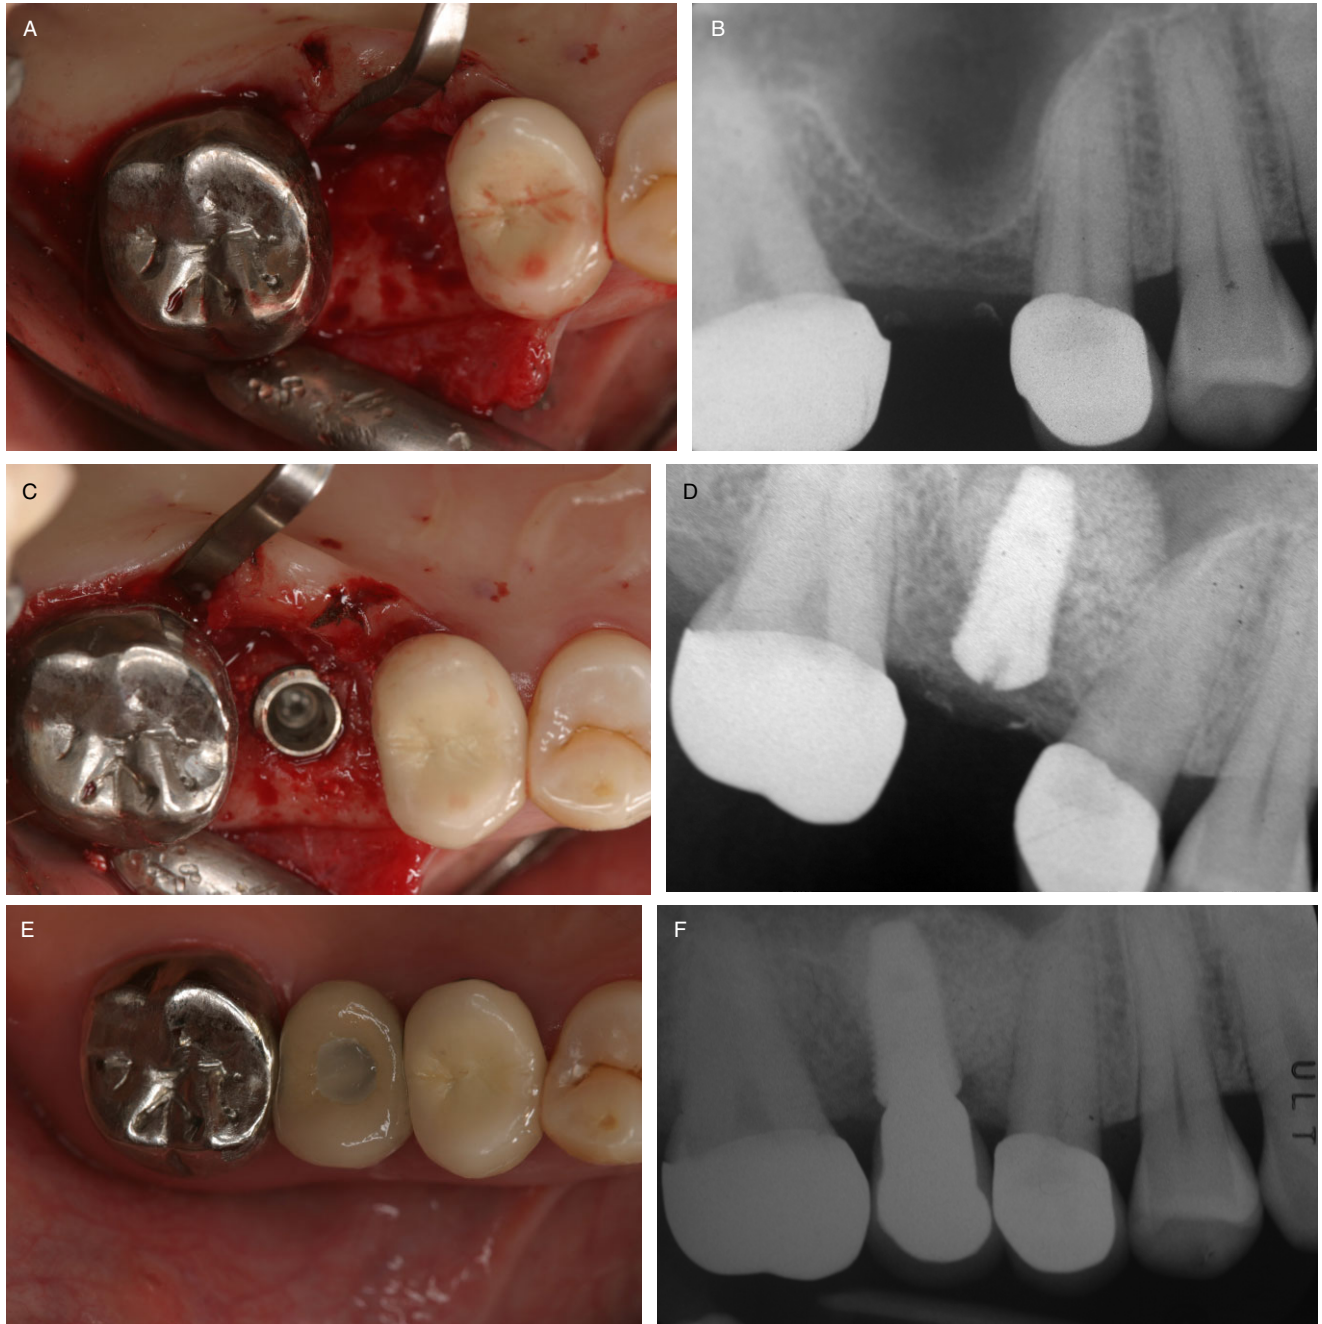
A and B, Clinical photograph and periapical radiograph taken prior to crestal approach sinus lift and simultaneous implant placement. Note the severity of maxillary sinus pneumatization prior to sinus lift procedure. C and D, Clinical photograph and periapical radiograph taken immediately after crestal approach sinus lift using beta tricalcium phosphate and simultaneous implant placement. E and F, Clinical photograph and periapical radiograph taken at the time of crown installation at 9 months after sinus grafting.
